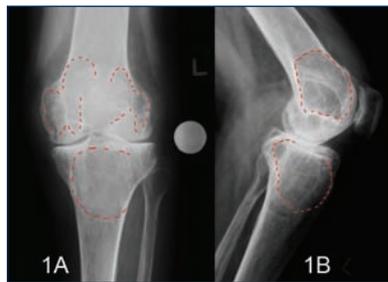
Antero-posterior (1A) and lateral (1B) pre-operative radiographs demonstrating diffuse joint space narrowing, joint effusion and large cystic lesions (red dots).
